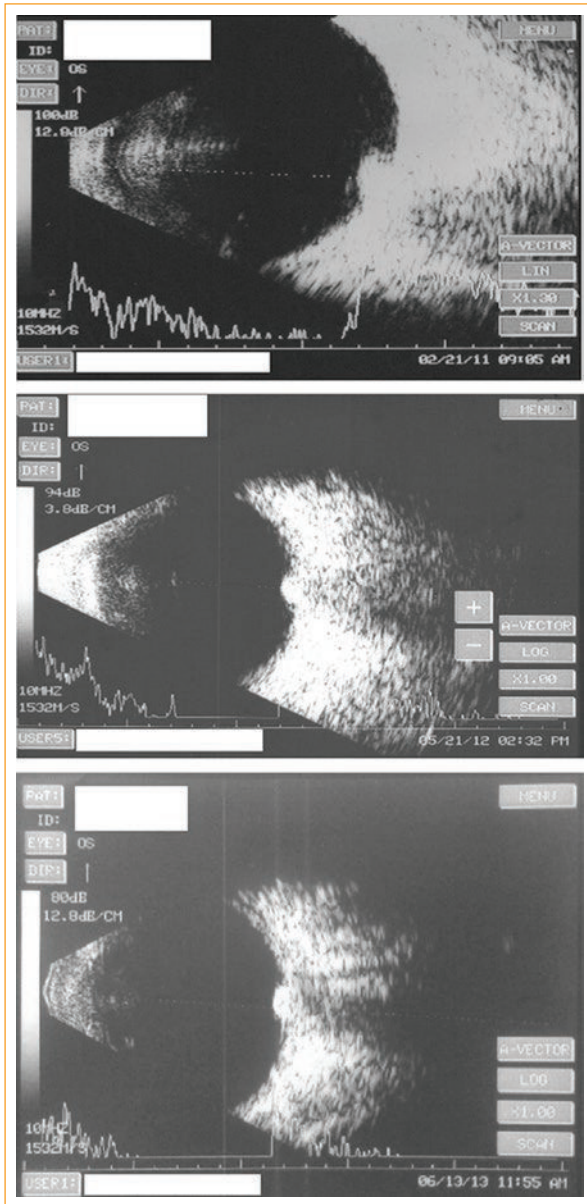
Mode-B ultrasound serial photographs of the left eye of a patient with optic nerve melanocytoma in 2011 (upper), 2012 (central) and 2013 (lower). This images evidence that there was no change in mass size, echogenicity, or choroidal excavation (courtesy of Dr. Zeiad Eldaly, from Eldaly, et al.²³).
